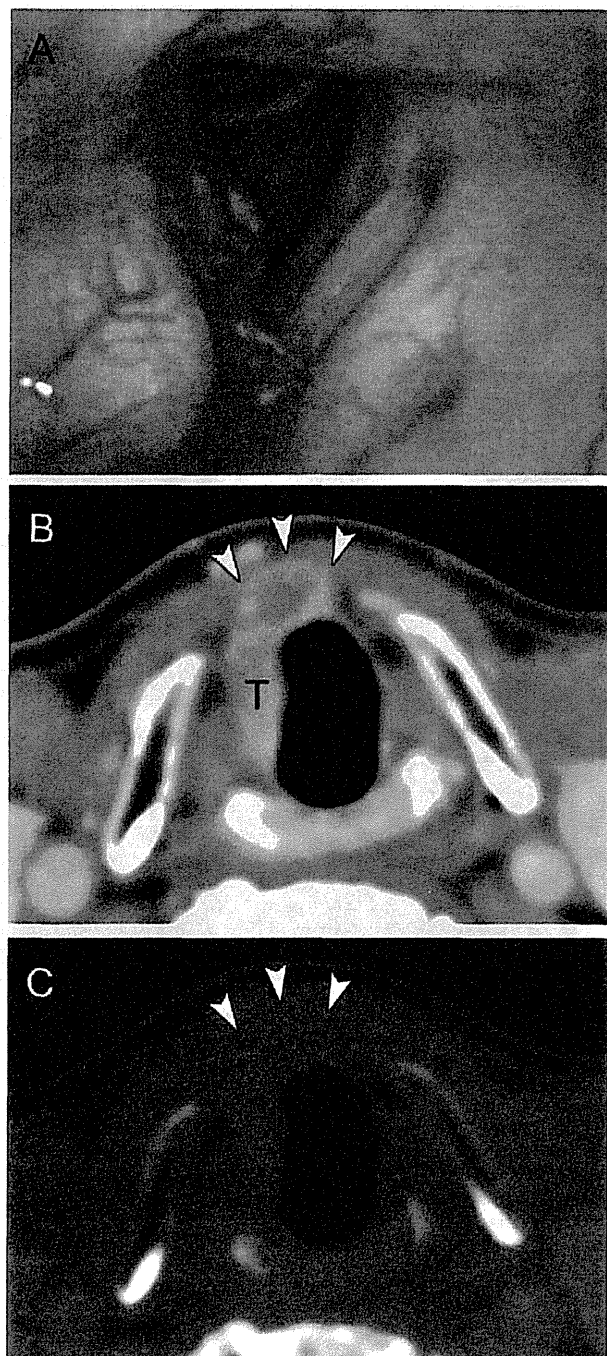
Extralaryngeal spread via the cricothyroid membrane on dual-energy CT in a 72-year-old man with right glottic cancer. (A) Nasopharyngolaryngoscopy demonstrates the tumor mass (T) at the right glottis. It is diagnosed clinically as T3. WA image (B) and IO image (C) at the subglottic level show that the tumor has spread submucosally into the extralaryngeal soft tissue (arrowheads) via the cricothyroid membrane, and is therefore diagnosed as T4a.
